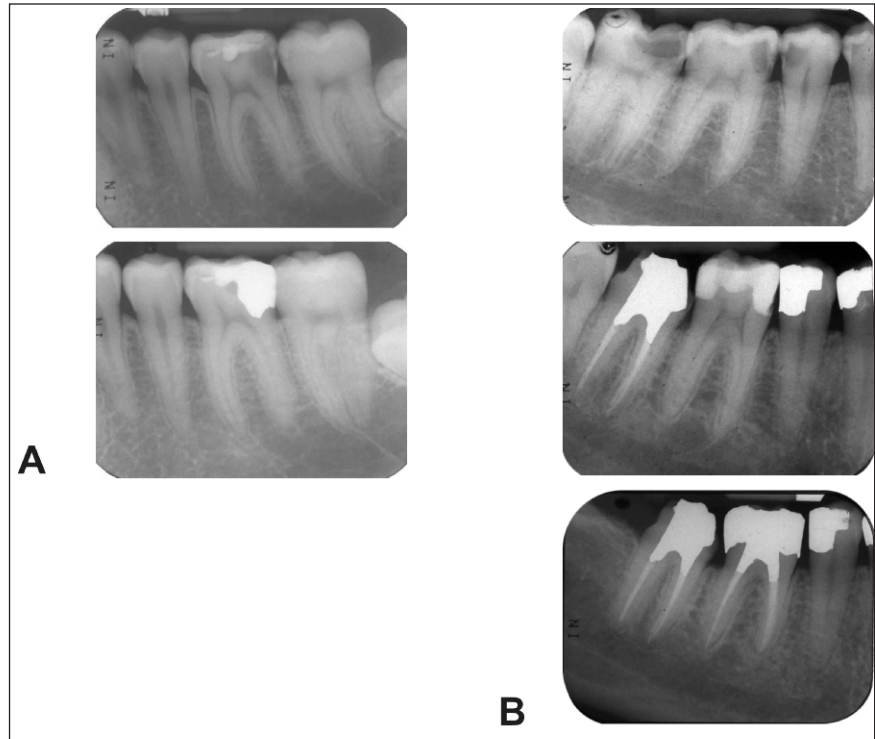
Examples of radiographic appearance of teeth included in this study. A: Case 1 (tooth #19) showed no apical pathosis before pulp capping and at recall. B: Case 2 (tooth #30) tested positive to cold initially and was treated with an MTA pulp cap. However, the tooth became painful before the scheduled recall appointment and a root canal treatment was performed.
